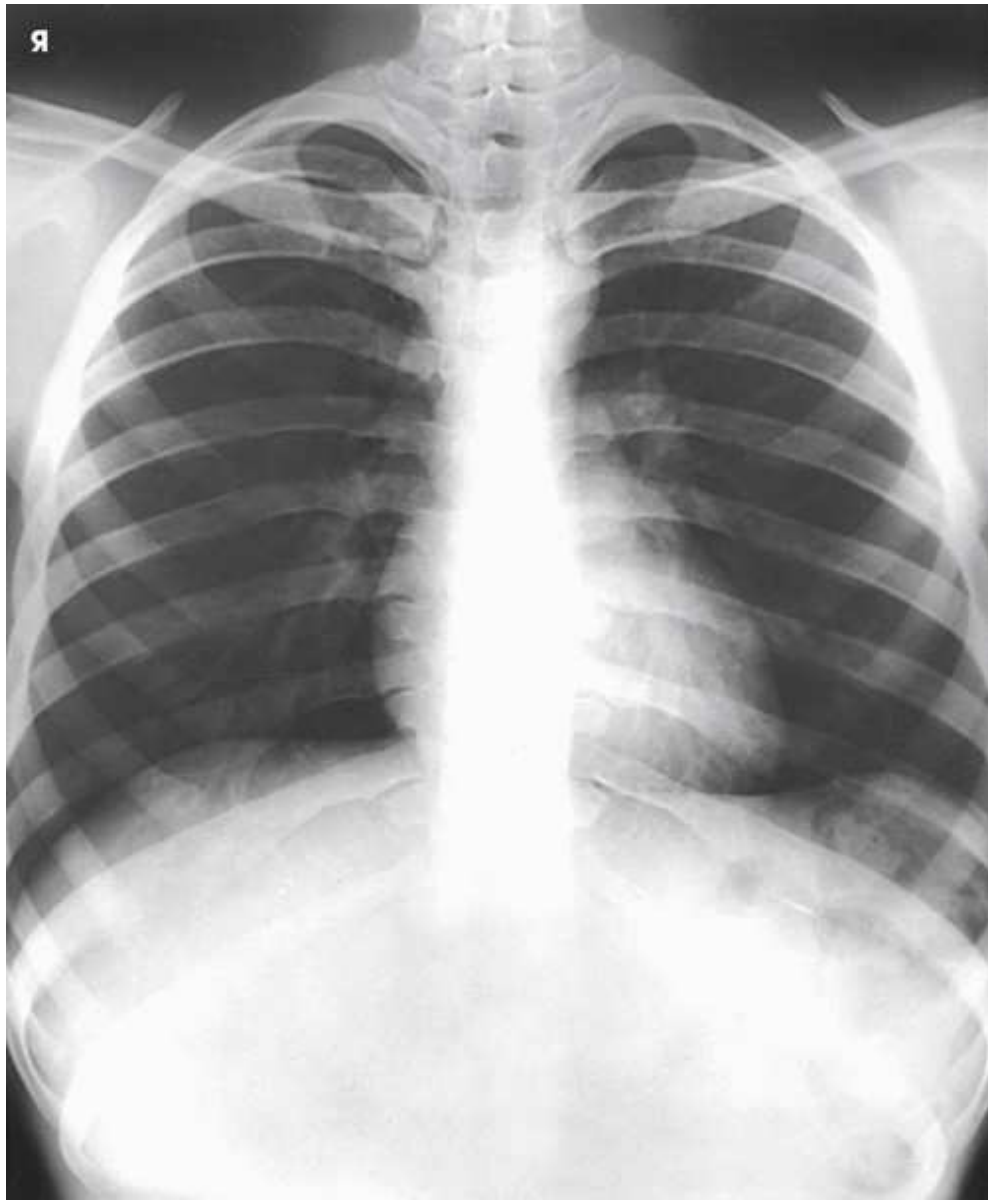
Prone chest radiograph. Diaphragm is superior when compared to [Fig. 3.23](#).
